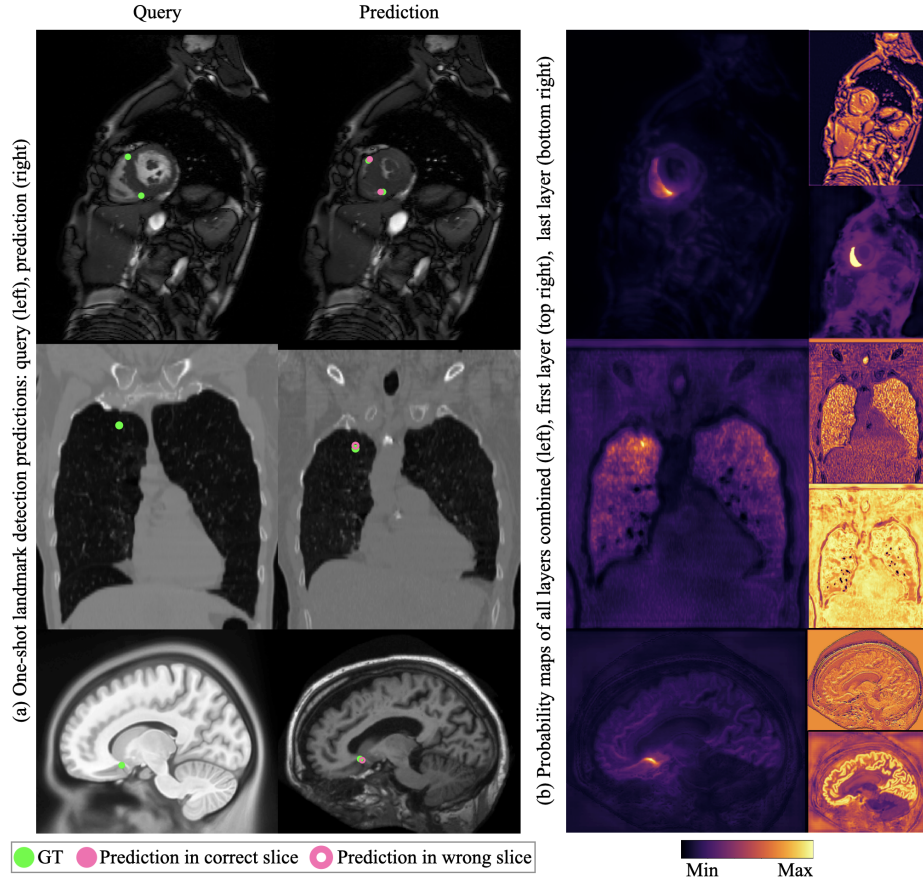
(a) Example one-shot landmark detections with average performance for each application considered: cardiac MRI, lung CT, brain MRI. Queried landmarks are indicated on the left images and the detected and ground-truth correspondences on the right images. (b) Probability maps of the combination of all layers, the first layer only and the last layer only for the examples in (a) (for one of the two points in cardiac MRI).
